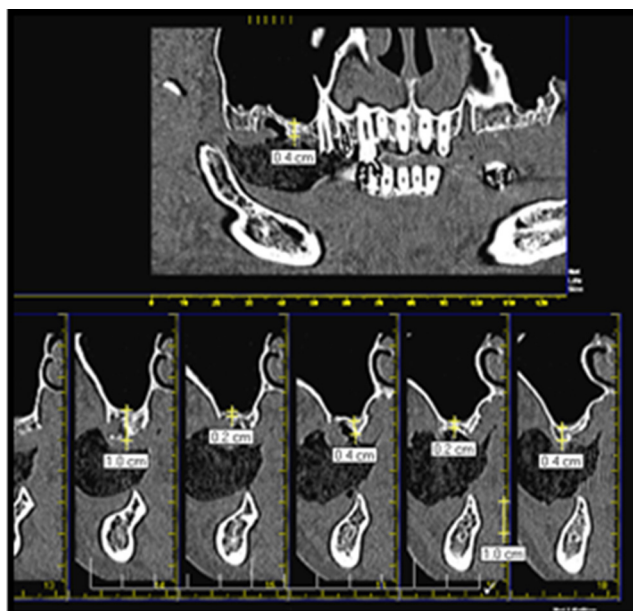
A preoperative CT scan showing the residual ridge height measurement.
